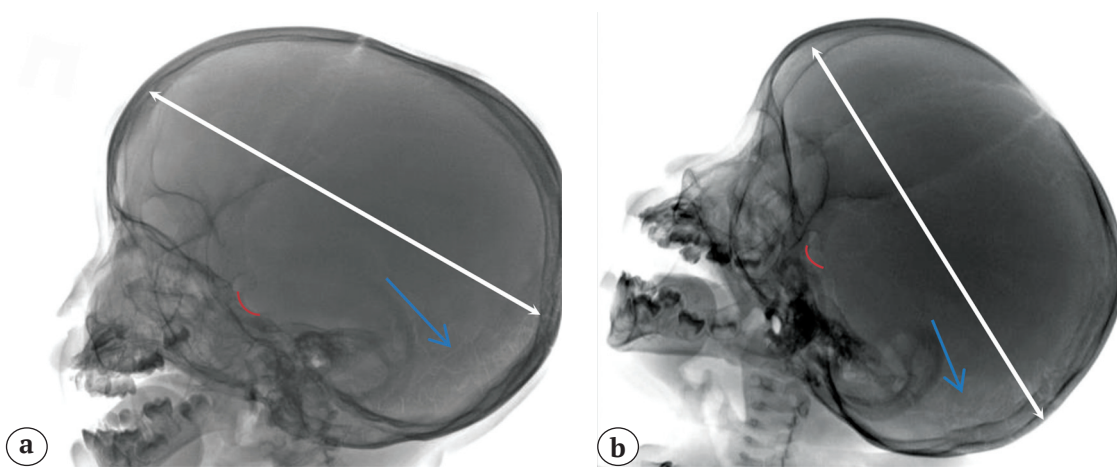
Lateral X-rays of the skull of patients 1 (a) and 2 (b): dolichocephaly (white arrows); an elongated sella turcica (red lines); vermian bones (blue arrows).
